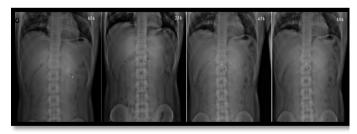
Radiographic images showing the presence of BaSO4loaded sustained release effervescent floating bilayer tablets of nateglinide in the stomach of volunteer-A at different time points (the location of the tablet is shown with an arrow).
